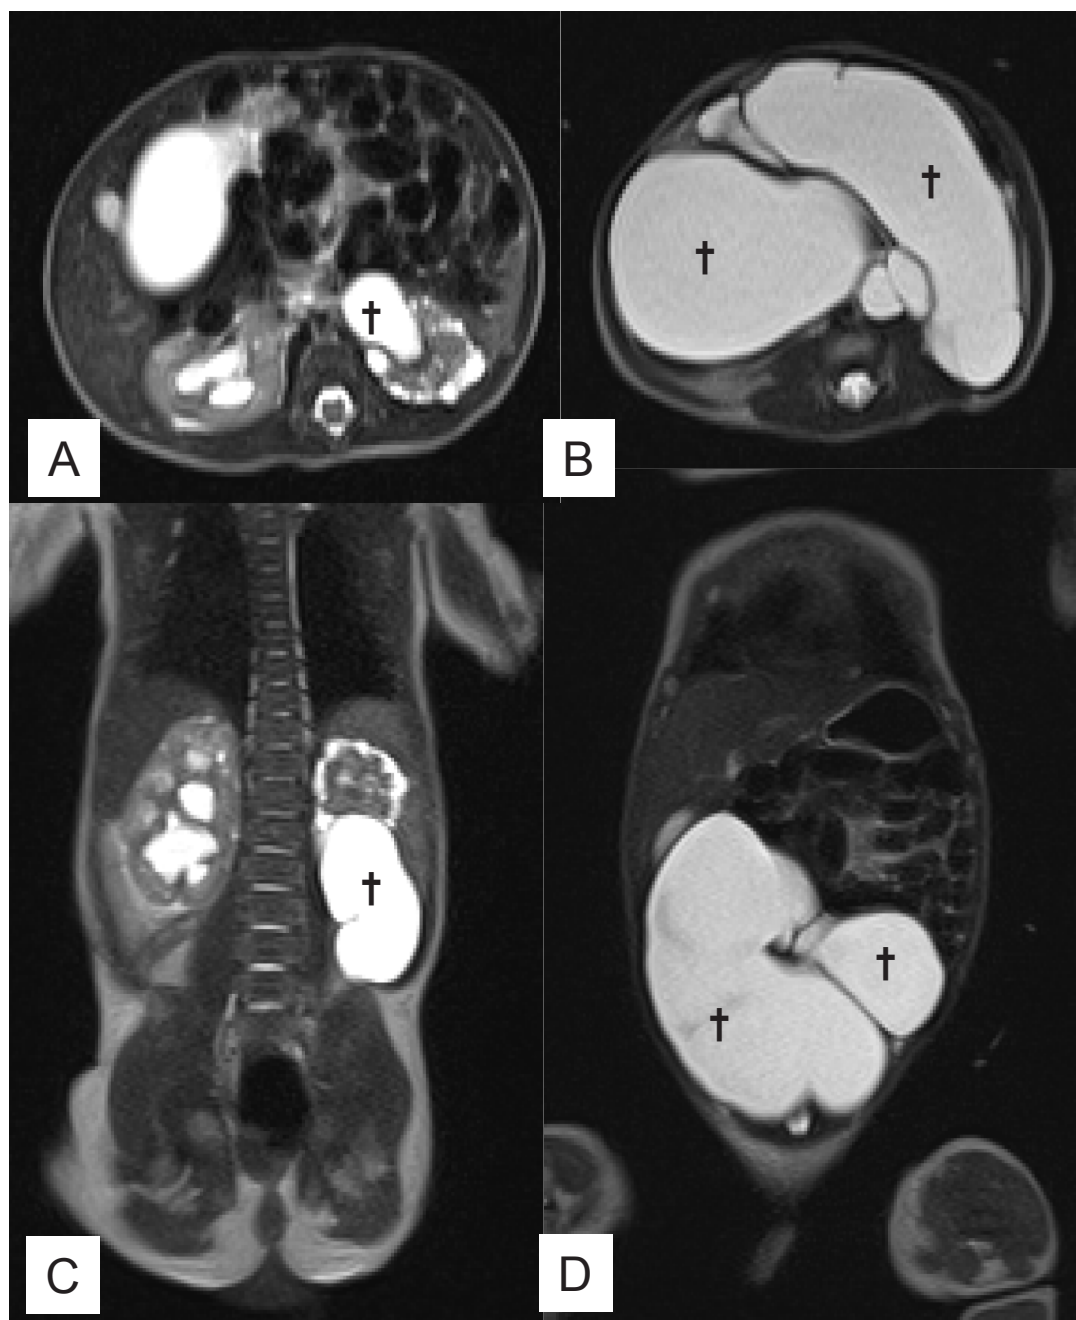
MRI on the 1st day after birth.
